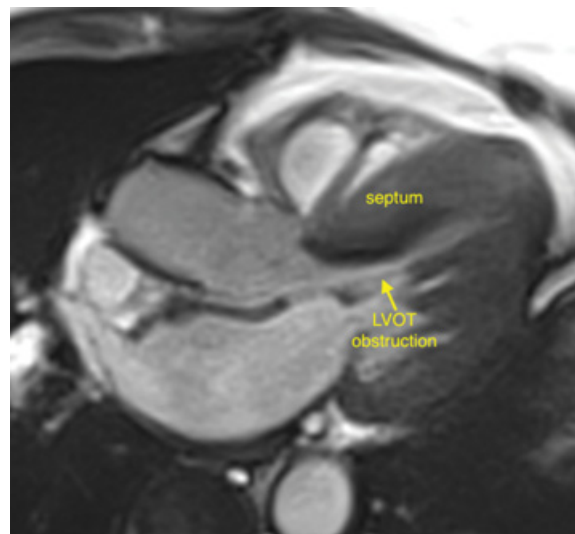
Hypertrophic cardiomyopathy. Magnetic resonance imaging of severe hypertrophic cardiomyopathy resulting in left ventricular outflow tract obstruction. Courtesy of Michael Taylor, MD.
